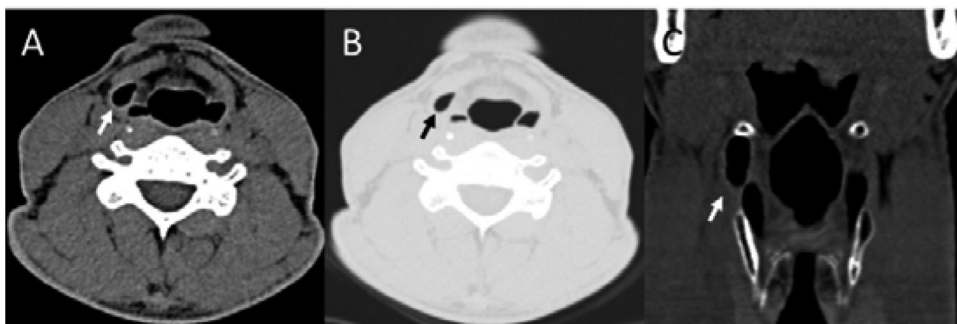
Axial CT image in soft tissue window (A) and lung window (B) and coronal CT image in soft tissue window (C) of a child with a laryngocele. The images show an air-filled well-defined mass in the lateral aspect of the superior paralaryngeal space (A, B) in keeping with a dilated laryngeal saccule. Note that the mass extends beyond the superior border of the thyroid cartilage (C) but remains confined to the larynx and therefore represents an internal type laryngocele.
